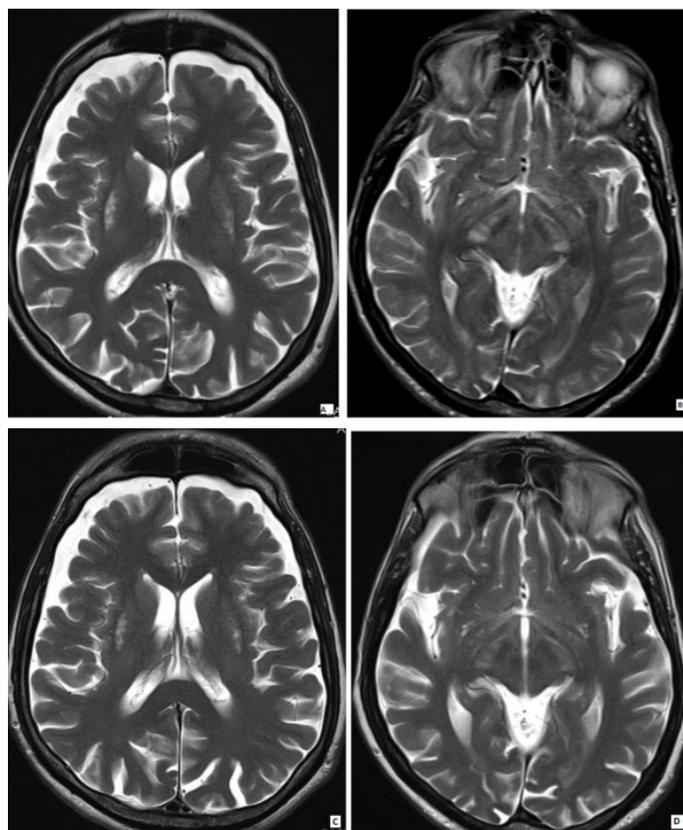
Hyperintense foci compatible with copper accumulation at the basal ganglia (Figure 2a) and midbrain (Figure 2b) that can be seen on the axial T2-weighted brain MR image of 53-year-old male patient who underwent liver transplantation due to Wilson's cirrhosis. No changes in the findings are detected on post-transplant brain MRI (Figure 2c and Figure 2d).
